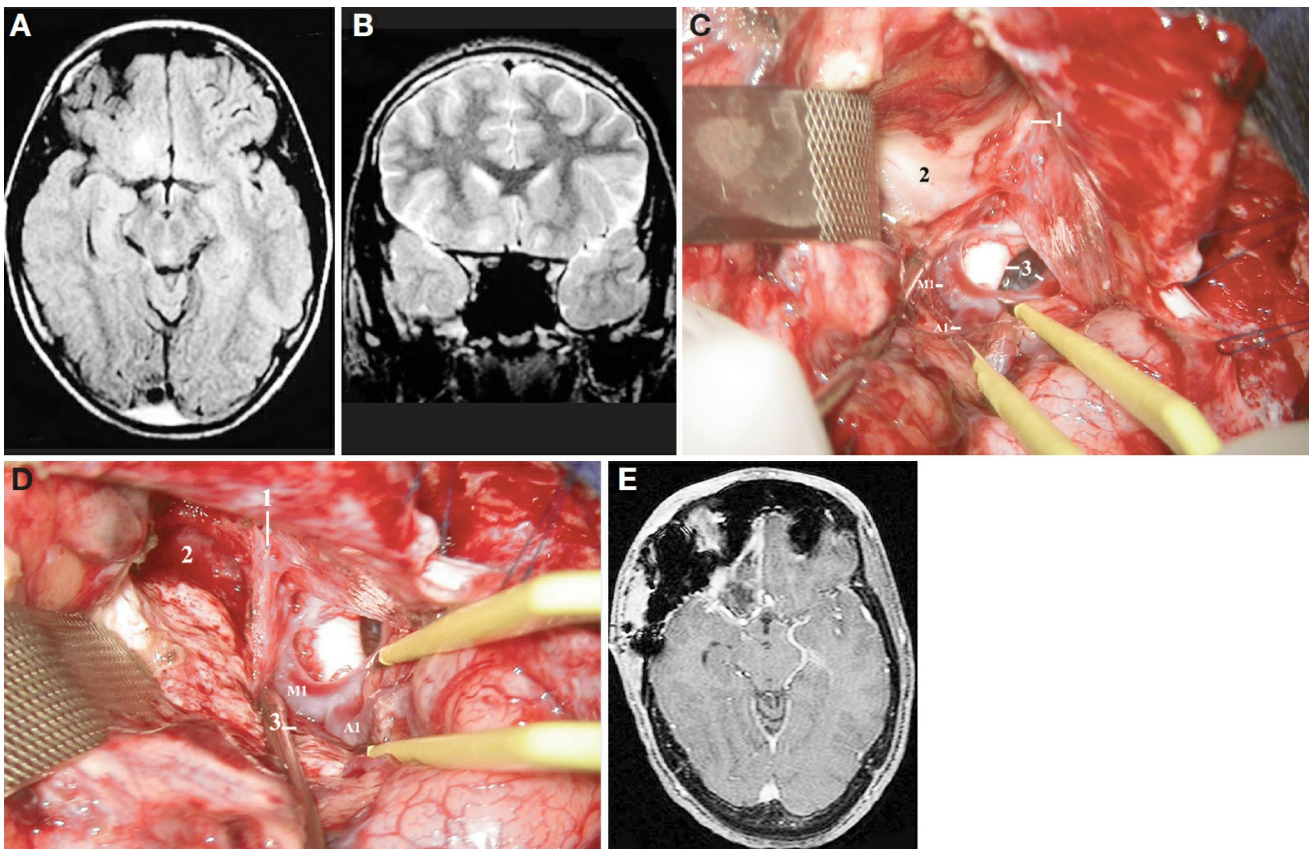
A, axial MRI scan. There is an increase in signal over the posteromedial orbital lobule. B, coronal MRI scan. There is a thin layer of white matter separating the suspicious area (corresponding to the posteromedial orbital lobule) from the inferior portion of the caudate nucleus. C, intraoperative photograph of the second operation, after a right pterional craniotomy and dural opening. 1, olfactory tract; 2, suspicious tissue; 3, optic chiasm and carotid artery; M1, M1 segment of the MCA; A1, precommunicating segment of the anterior cerebral artery. At the tip of the suction tube is the posterior part of the olfactory tract. D, intraoperative photograph after removal of the posteromedial orbital lobule and the rectus gyrus. 1, olfactory tract; 2, anterior cerebral artery in the interhemispheric fissure; 3, lenticulostriate arteries arising from the carotid bifurcation; M1, M1 segment of the MCA; A1, precommunicating segment of the anterior cerebral artery. E, postoperative MRI scan performed 5 days after surgery showed the resection of the frontobasal area, just anterior to the carotid artery bifurcation. (Images courtesy of AL Rhoton, Jr.)
